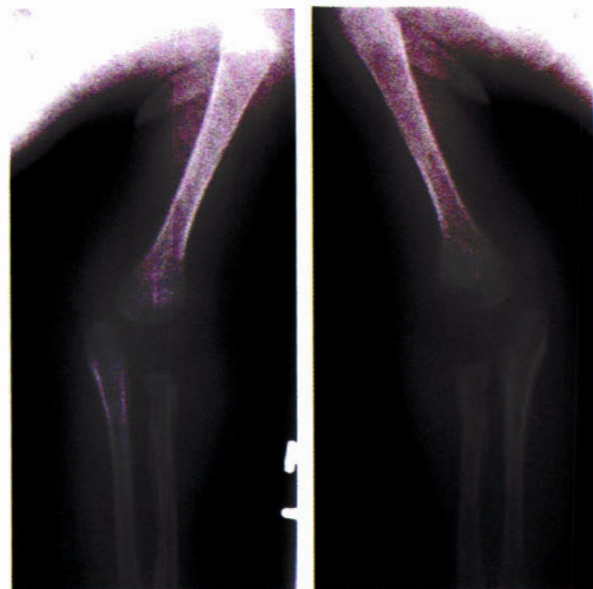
Pseudoparalysis — Radiographs of the left and right upper extremities demonstrating methaphyseal erosions of the distal part of the humerus and the proximal part of the ulna.
